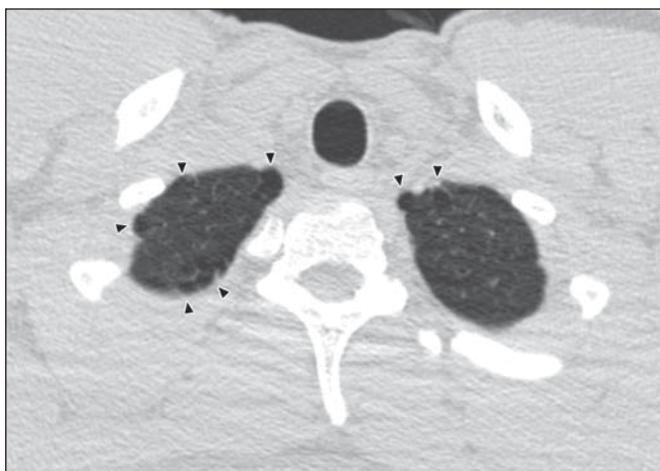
Inspiratory CT scan of chest shows bilateral paraseptal emphysematous lesions in lung apices (*arrowheads*) seen as focal regions of low attenuation in 35-year-old man who is current smoker with 4.4 pack-years of smoking history.
